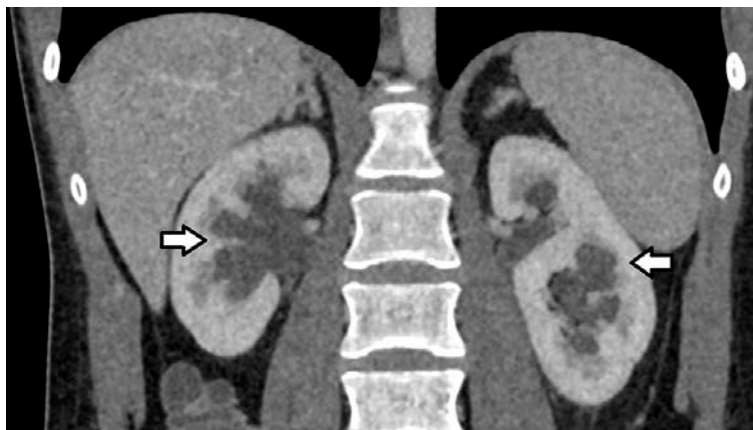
Coronal CT image of the abdomen with contrast demonstrates bilateral hydronephrosis
